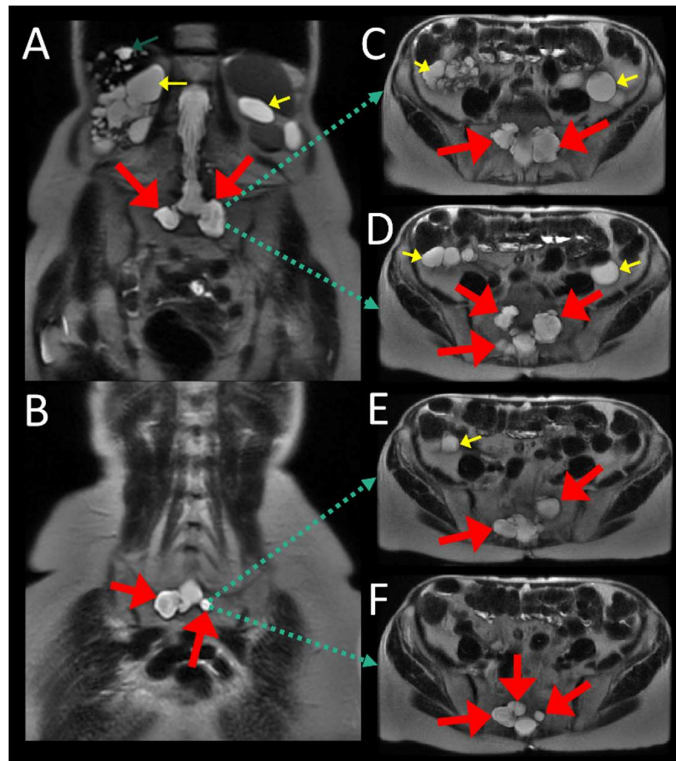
A 73-year-old female with ADPKD reporting a remote history of severe headache lasting 2 weeks with A, B) coronal and C,D,E,F) sequential axial T2-weighted SSFSE (single shot fast spin echo) images showing multiple large sacral spinal meningeal
